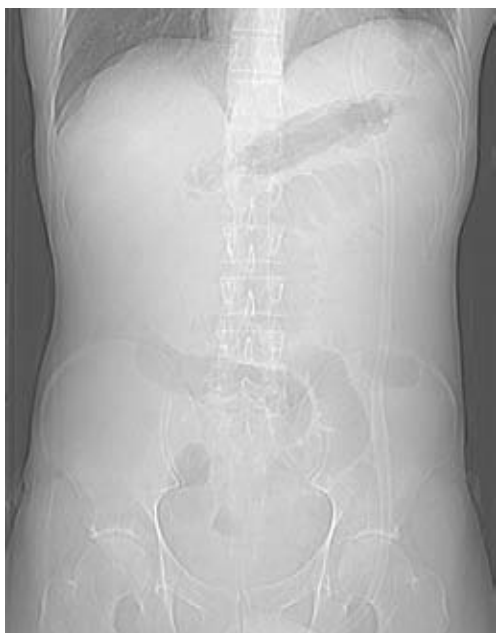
AP scout view of abdominal CT – coronal plane. Distension of the small bowel loops – bowel obstruction.
